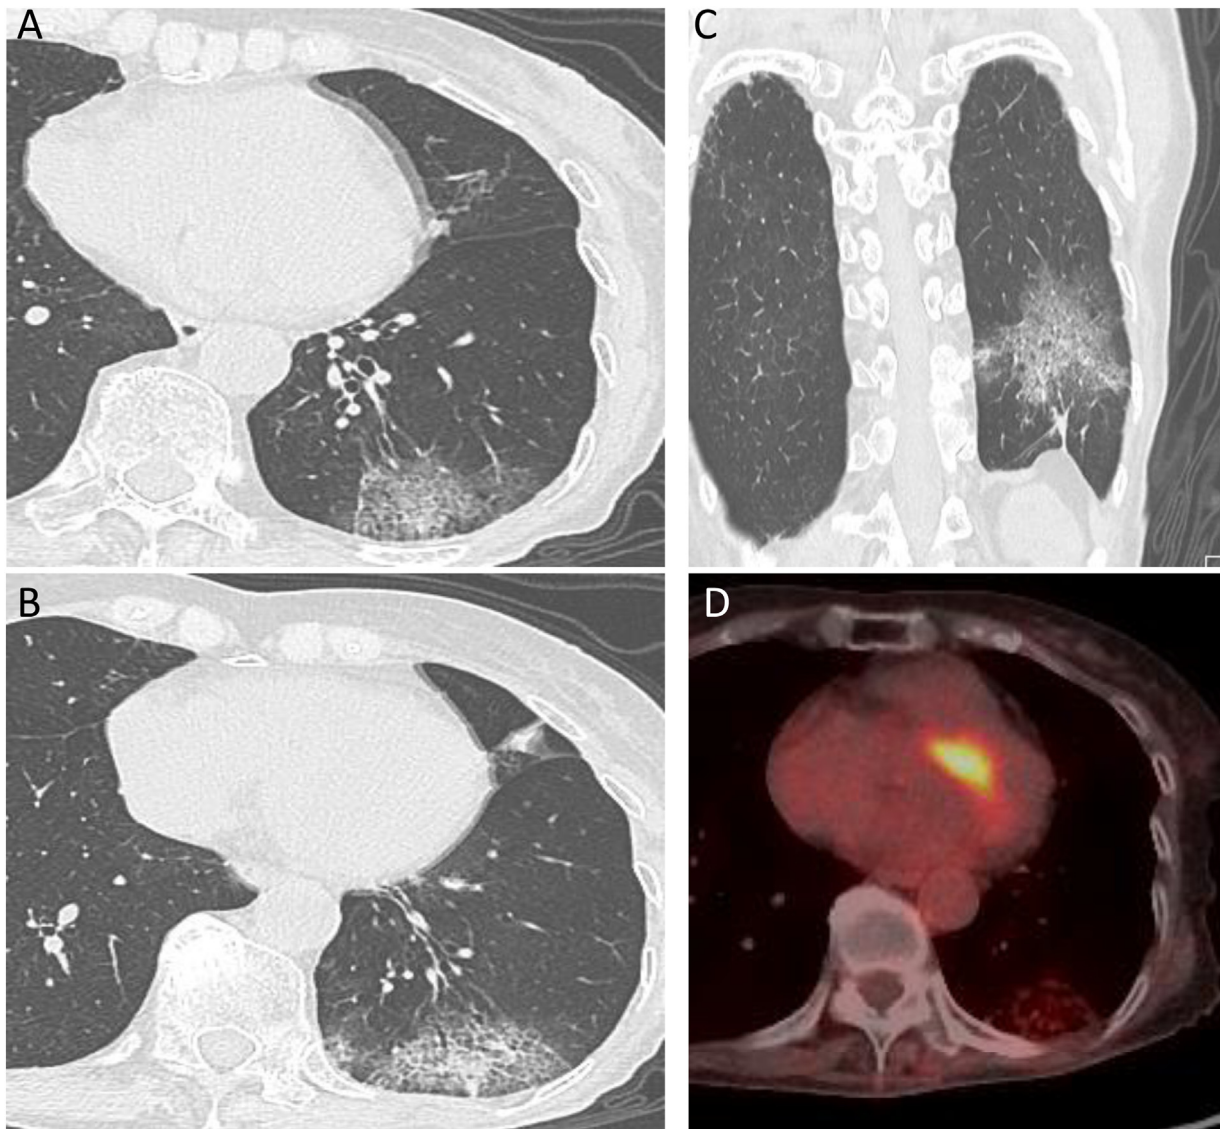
(A, B, C) Chest computed tomography. Left lower lung shows a 6-cm-diameter pure ground-glass opacity. (D) Positron emission tomography/computed tomography. The left lower lung mass shows an unremarkable uptake of 18F-fluorodeoxyglucose; the early maximum standardised uptake value of the mass was 1.9.
